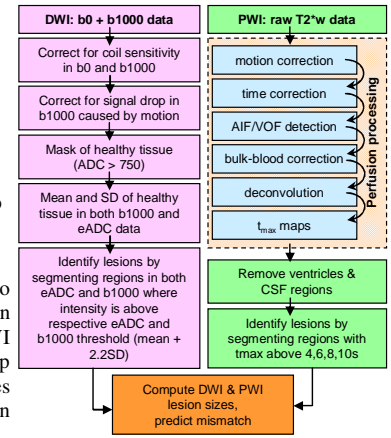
Processing of DWI and PWI data for mismatch analysis
